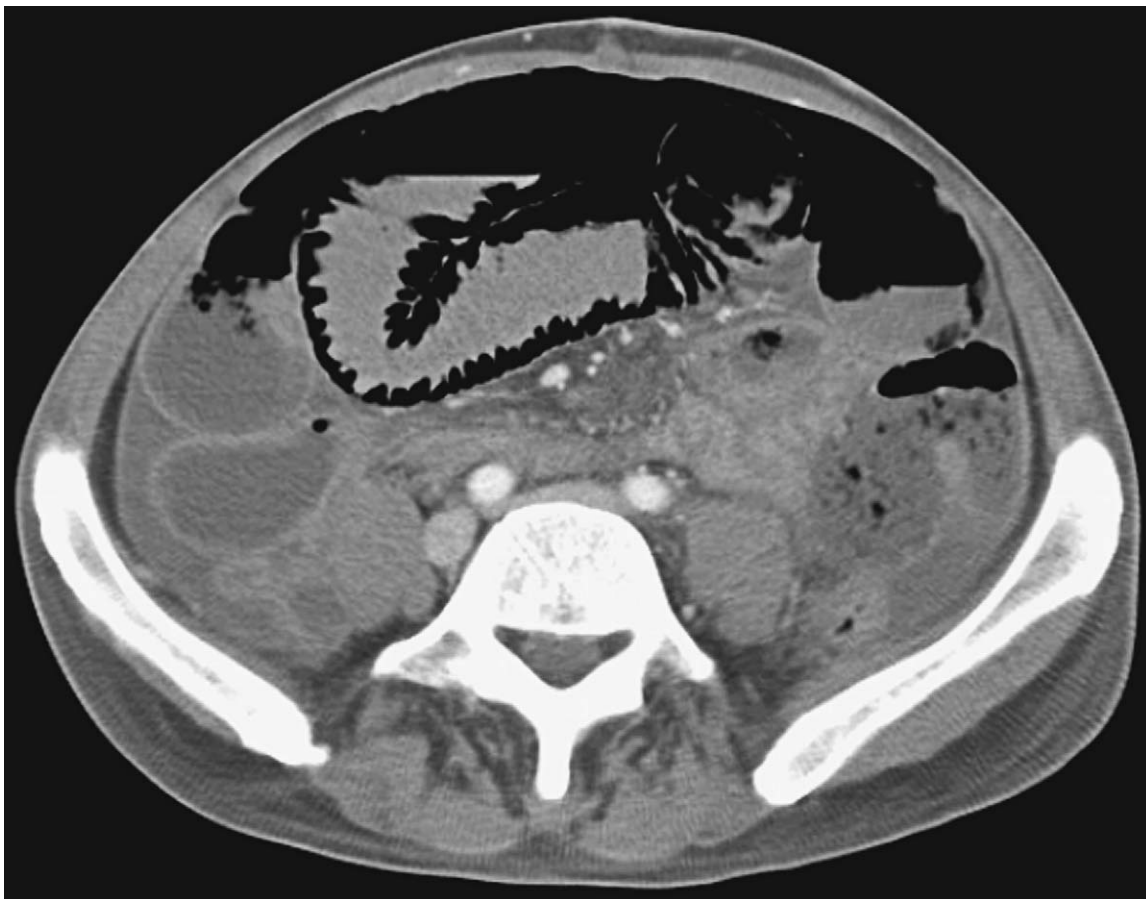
CT scan demonstrating extensive small bowel pneumatosis and pneumoperitoneum.
